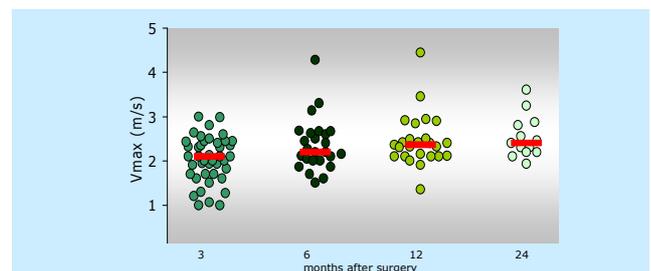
Doppler peak flow velocity in the conduit during follow-up
